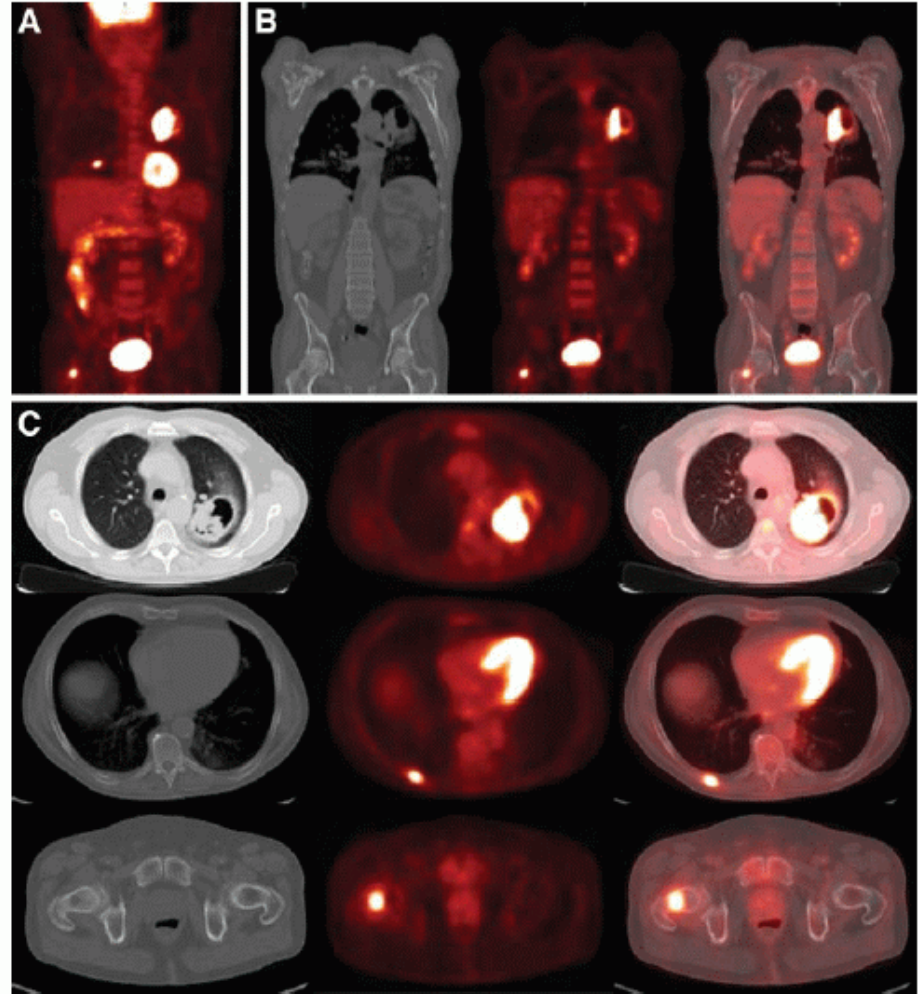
Lung cancer with osseous metastases. Hypermetabolic cavitary lung mass is seen in left upper lobe (A–C). Maximum-intensity-projection image (A) demonstrates additional lesions in contralateral thorax and hip. Additional focus of hypermetabolism is seen in right femoral neck (A–C) and corresponds to subtle lytic lesion on CT. Axial images (C) show hypermetabolism in right posterior 8th rib without osseous changes on CT.
